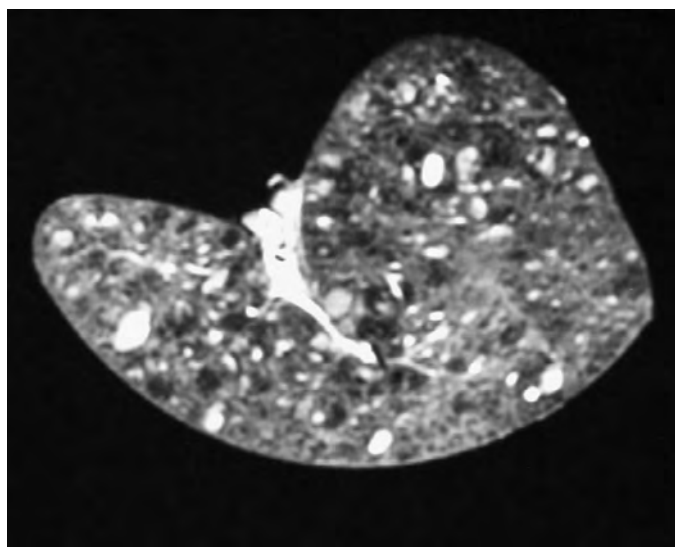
Peliosis hepatis. In the T2-weighted MR image of a surgically resected spleen with peliosis, the signal intensity of the innumerable, subcentimeter, blood-filled spaces is extremely variable.
